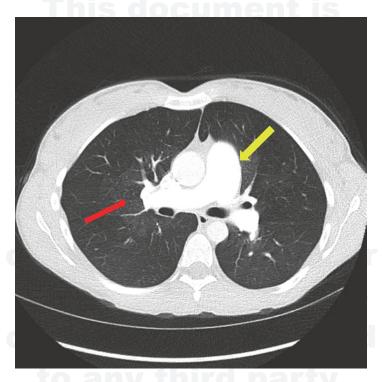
CT Chest with pulmonary embolism protocol reveals an enlarged pulmonary artery (yellow arrow) compared to the aorta and bilateral peripheral mosaicism (red arrow) which are both seen in pulmonary hypertension
